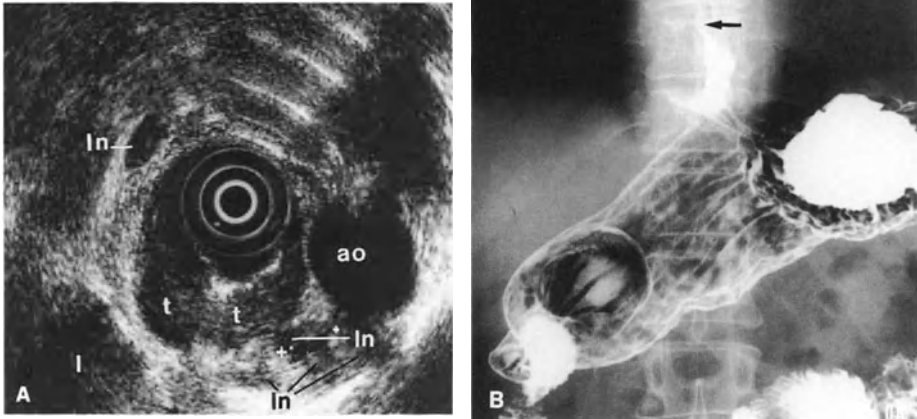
A Endoscopic sonogram showing a hypoechoic polypoid transmural tumor (*t*) adjacent to the aorta (*ao*) with multiple lymph nodes (*ln*). Note a large, suspicious lymph node on the contralateral side of the aorta. *l*, liver. B Corresponding radiogram, showing the stenotic lesion in the distal esophagus (*arrows*)
